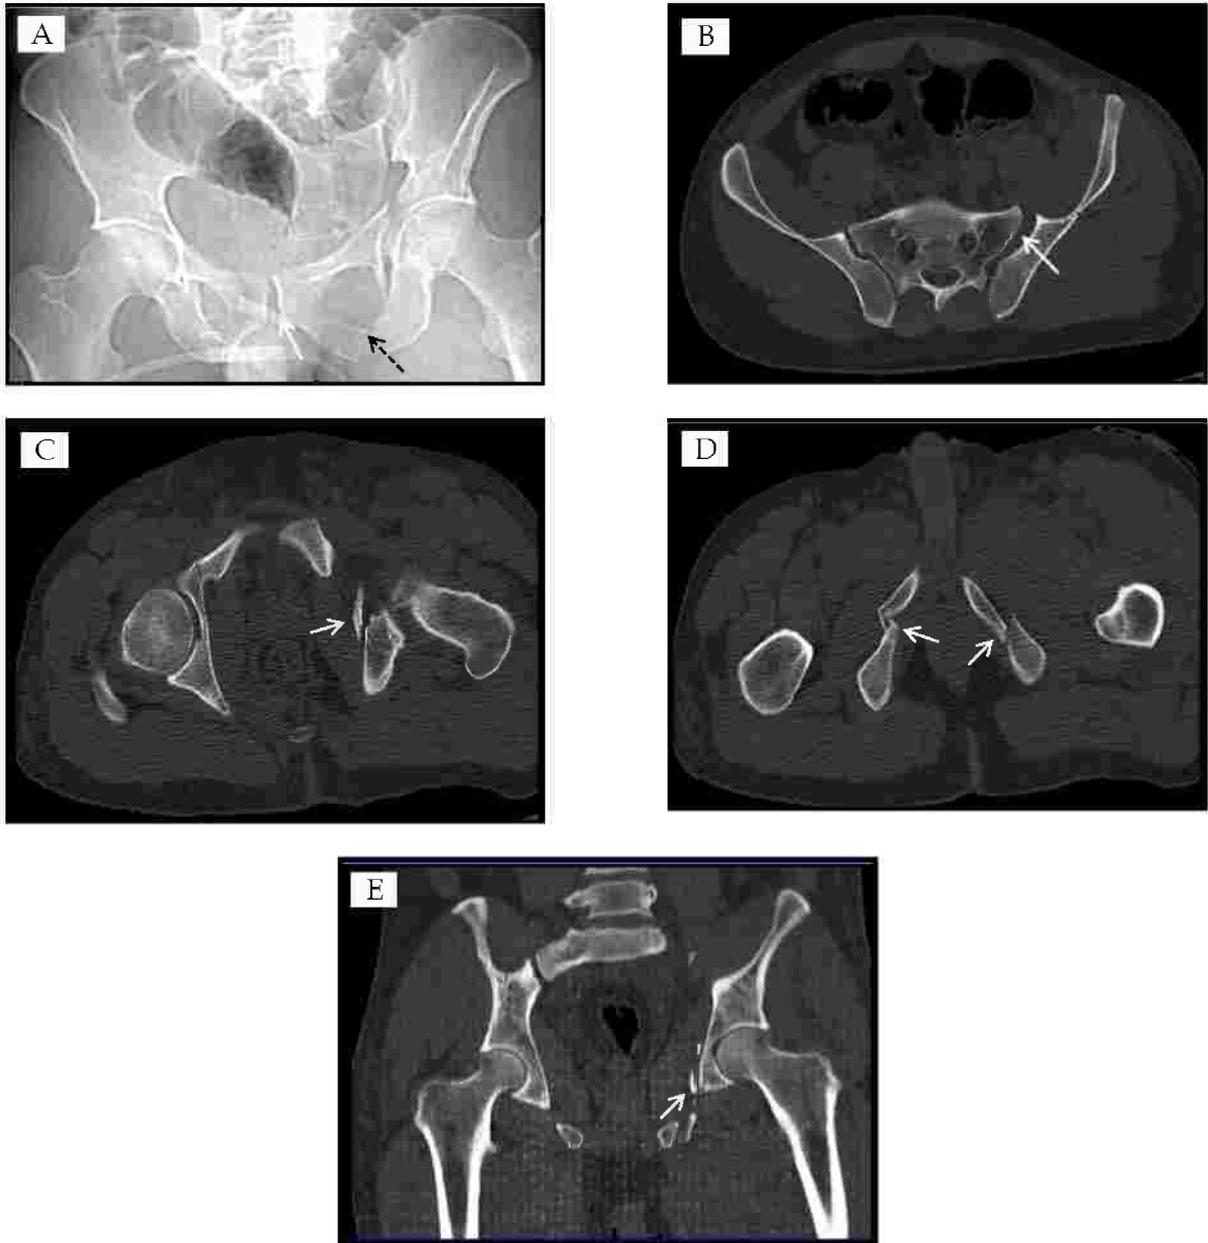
30 years old male with history of falling from height, plain x-ray anteriorposterior view in (A) show pubic symphysis diastasis (short white arrow), and a fracture of the left inferior pubic rami (black arrow), (B,C,D) Axial bone window CT of the pelvis showing left sacroiliac diastasis which didn't seen in plain radiography in (B) and both inferior pubic rami in (C,D) , (E) Coronal CT of the pelvis show the fragments.
